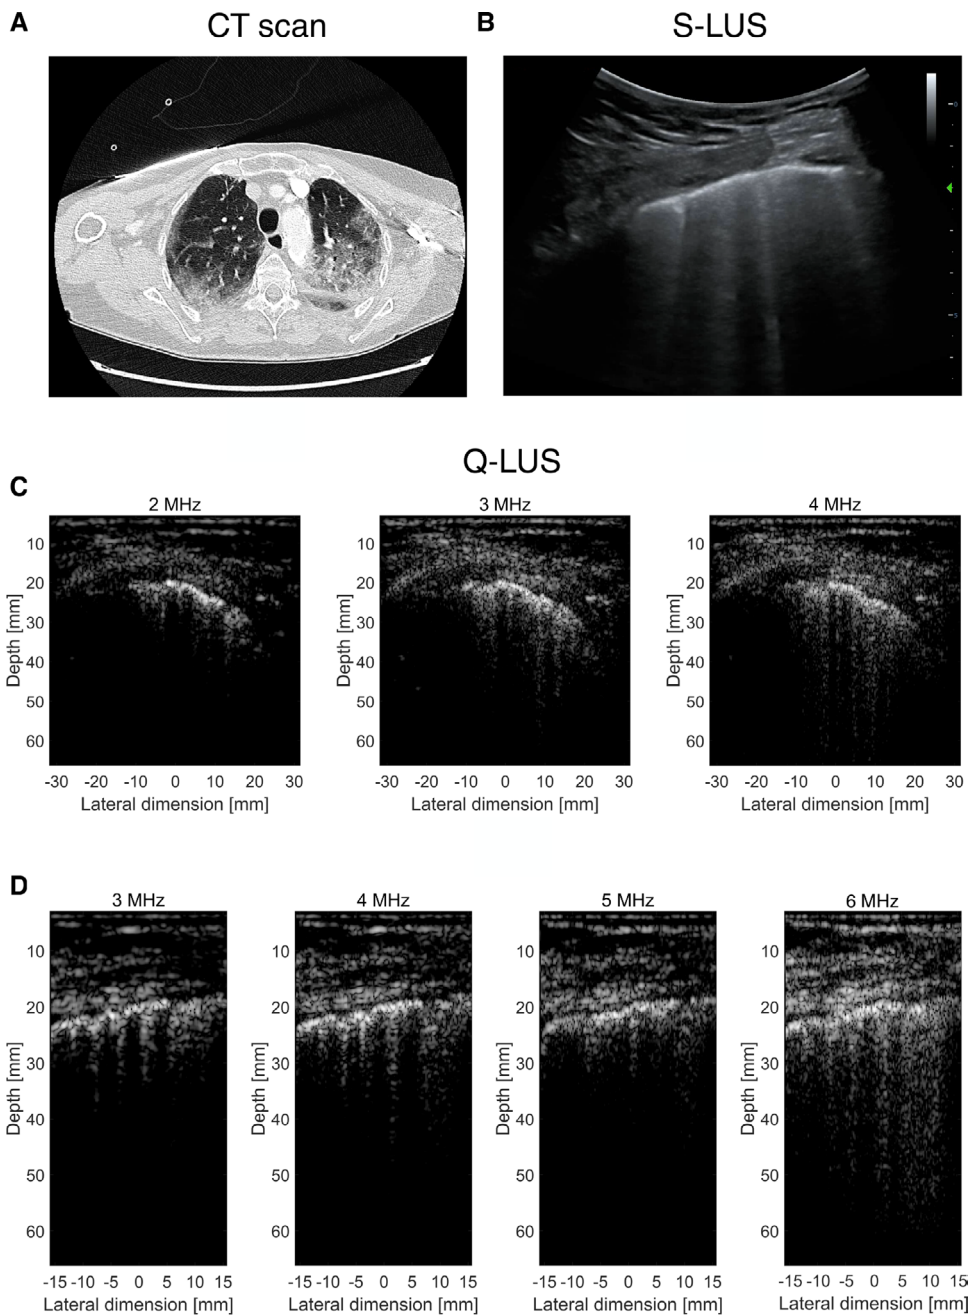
Images acquired by different imaging modalities. CT scan in a), S-LUS in b), Q-LUS acquired with the convex probe at 2, 3, and 4 MHz in c), and Q-LUS acquired with the linear probe at 3, 4, 5, and 6 MHz in d), both displayed at 35-dB dynamic range.
